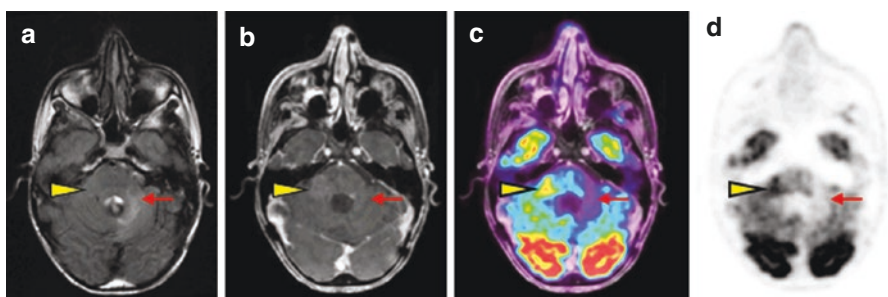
FDG-PET/MRI in a 20-year-old male with suspected recurrence of medulloblastoma. A representative FLAIR image (a) demonstrates subtle signal hyperintensity in the region of the right cerebellar peduncle (*yellow arrow head*) and more conspicuous hyperintensity in the left cerebellar hemisphere (*red arrow*). There is contrast enhancement in the right middle cerebellar peduncle but not in the left cerebellar hemisphere (b). Fused FDG-PET/MRI (c) and PET only (d) images demonstrate increased FDG uptake in the right cerebellar peduncle lesion (*yellow arrow head*) but not the left cerebellar hemisphere lesion (*red arrow*), most consistent with recurrence and treatment effect in these locations, respectively. (a) FLAIR; (b) post-contrast T1; (c) fused FDG-PET/MRI; (d) FDG-PET
